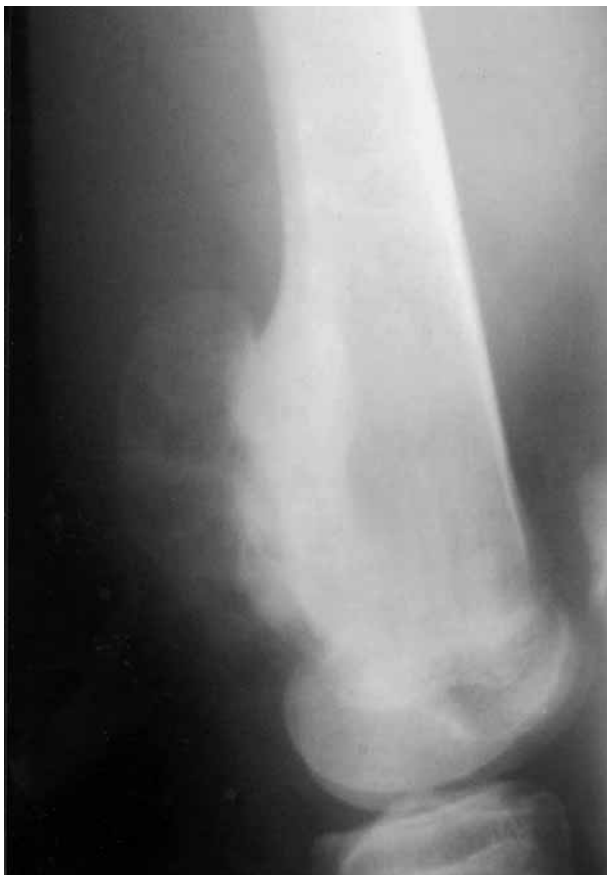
Lateral radiograph of the left femur : irregular bony protuberance capped with a translucent mass having the same density as adipose tissue.
